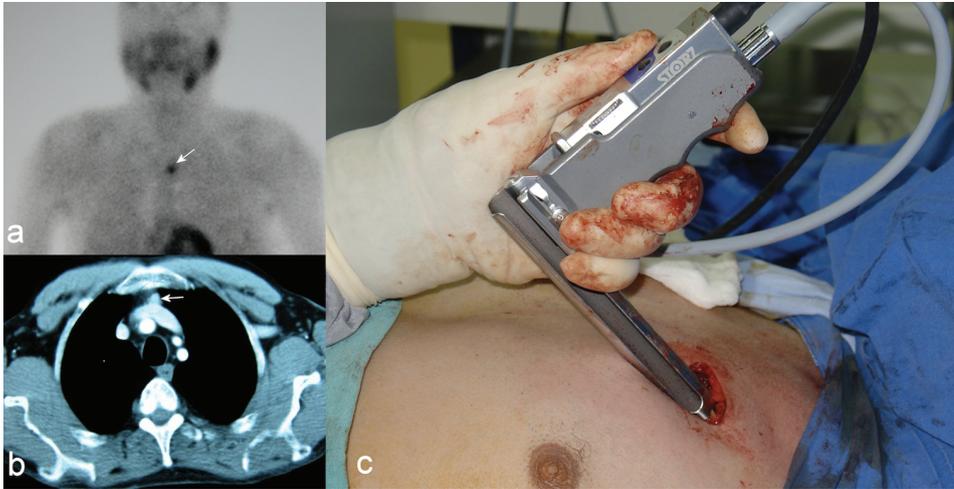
(a) Tc 99m MIBI parathyroid scintigraphy, an intense focus in mediastinum, (b) thorax CT, a small mass located in front of the left brachiocephalic vein, (c) operative view, parasternal video mediastinoscopy via parasternal incision.
